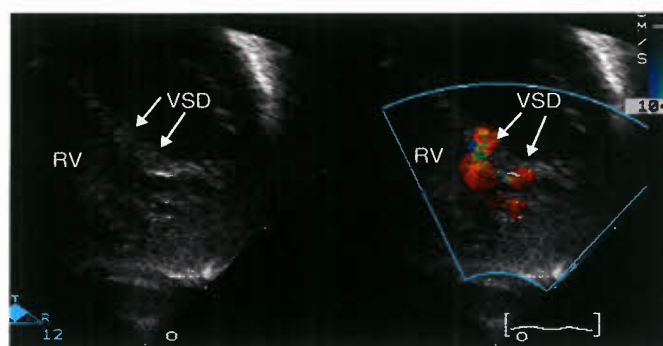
Subcostal short-axis view at the level of the midinterventricular septum demonstrating color Doppler interrogation of a moderate-sized as well as a smaller low-muscular VSD.
